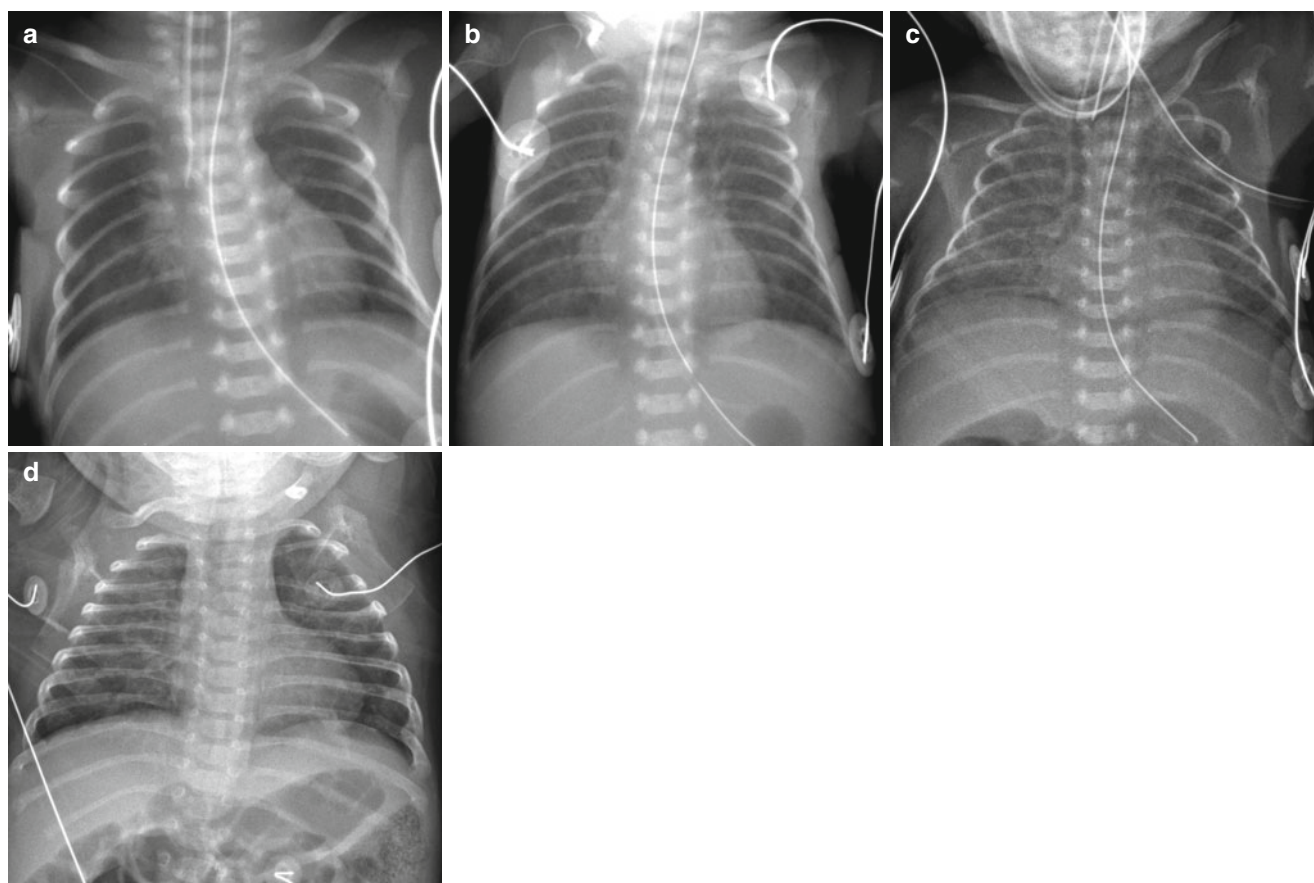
Immature lung syndrome in a neonate born at a gestational age of 23 weeks and 4 days. (a) Anteroposterior radiograph obtained on the day of birth shows ill-defined central lung opacities. (b) At 9 days
